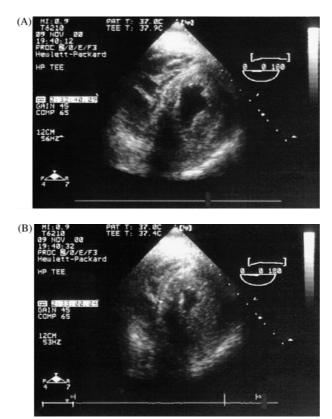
Transesophageal transgastric view showing marked concentric left ventricular hypertrophy with small cavity in diastole (A) and in systole (B).
